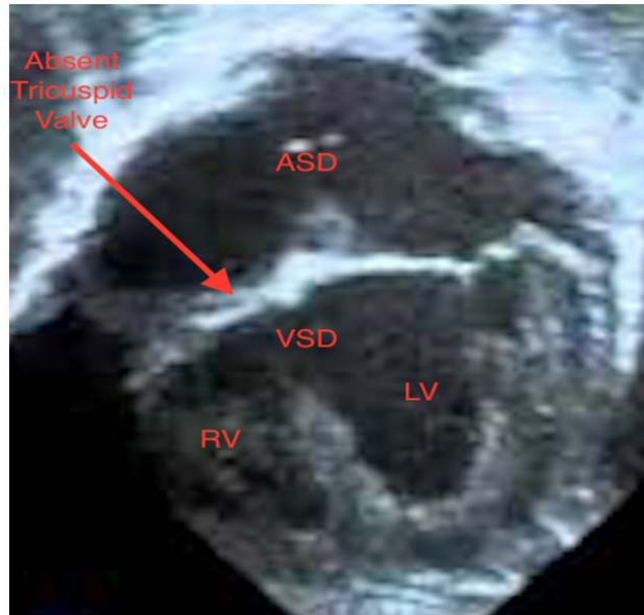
2-dimensional echocardiographic image of a child with tricuspid atresia
